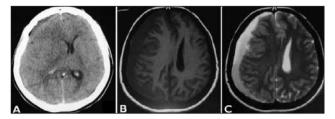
Brain CT (A) showed an isodense cSDH material of the right frontal region with 2 cm midline shift. Cranial MRI showed a 2 cm-thick T1-weighted (B) hypointense, T2-weighted (C) hyperintense cSDH overlying the right fronto-parietal lobe with 2 cm midline shift.
